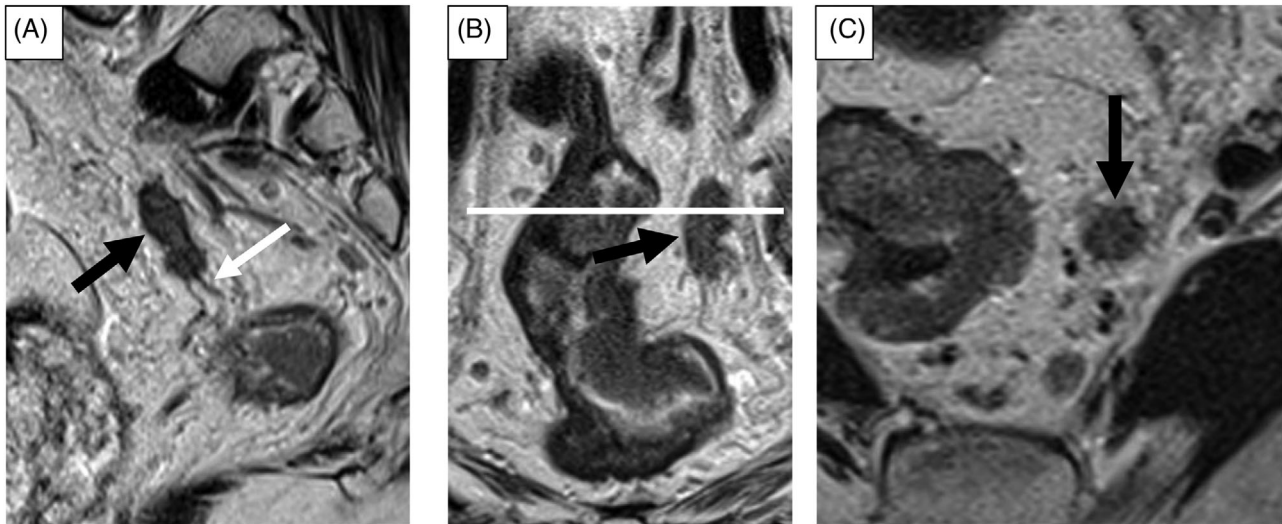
(A and B) This elongated mesorectal tumor deposit (black arrow) is clearly associated with veins (white arrows) on (a) sagittal and (b) coronal magnetic resonance imaging (MRI) images. However, when assessed in the axial plane only (c) as in pathology, it can easily be mistaken for a totally replaced lymph node. The axial slice position (white line) is shown on the coronal image.
